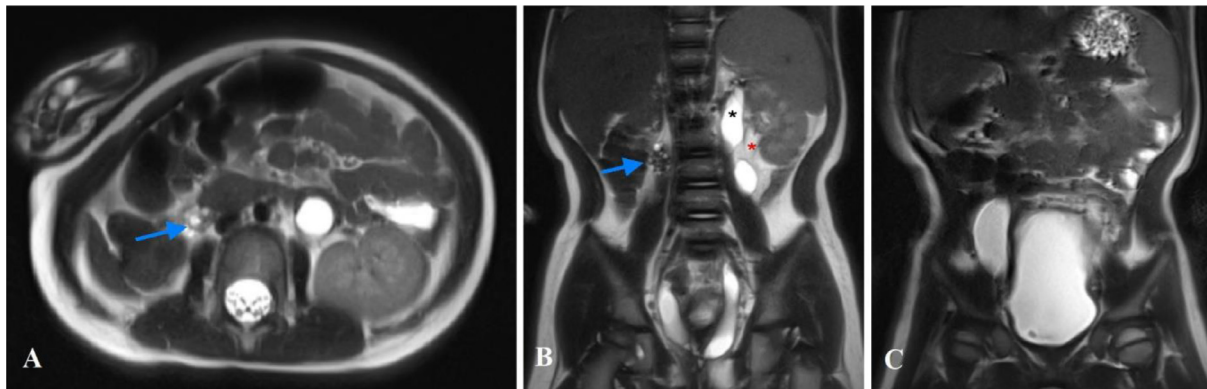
T2-weighted image. (A) and (B) Axial and coronal image showed a multicystic structure in the right flank area (blue arrows). The left kidney has 2 ureters, one at the upper pole (black asterisk) and the other one is at the middle pole (red asterisk). The ureter at the upper pole connected to the urethra. (C) Coronal image showed the blind ending ureter emerging from the urethra.
